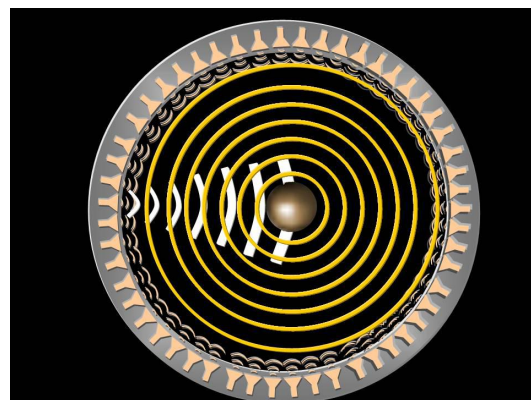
(b): In reality, when ultrasound pulses are directed into human tissue they scatter off the tissue in all possible directions (yellow wave fronts). By surrounding the target with sensors, all of the scattered wave fronts can be recorded. Consequently, much more information about the tissue can be extracted.
